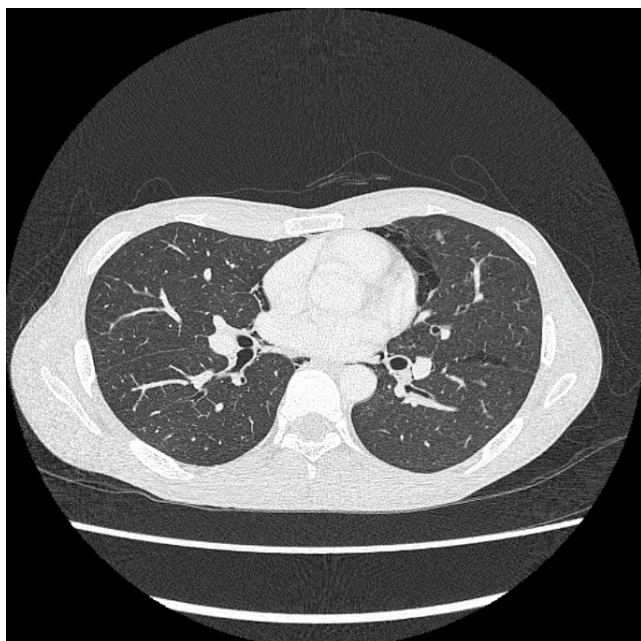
Axial cut of CT thorax in lung window. Thorax computed tomography scan showed pneumomediastinum over left cardiac border with intact lung parenchyma and absence of oesophageal or bronchi abnormalities.
